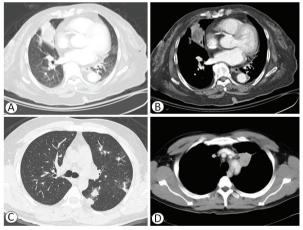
Different manifestations of pulmonary actinomycosis on chest computed tomography. (A) A 78y/o female presented at our hospital with chronic cough and generalized weakness. Lung cancer was suspected initially. Consolidation of the right middle lobe with central necrosis in the right lower lobe anterior basal segment was seen in 1 patient, and (B) central low attenuation was noted with a mediastinal window setting; (C) A 38 y/o male presented with productive cough for several months. Multiple ill-defined irregular nodular lesions at both lungs were seen on computed tomography; (D) A 51 y/o male presented with postcontrast homogeneous enhancement was seen in the left upper lobe.
